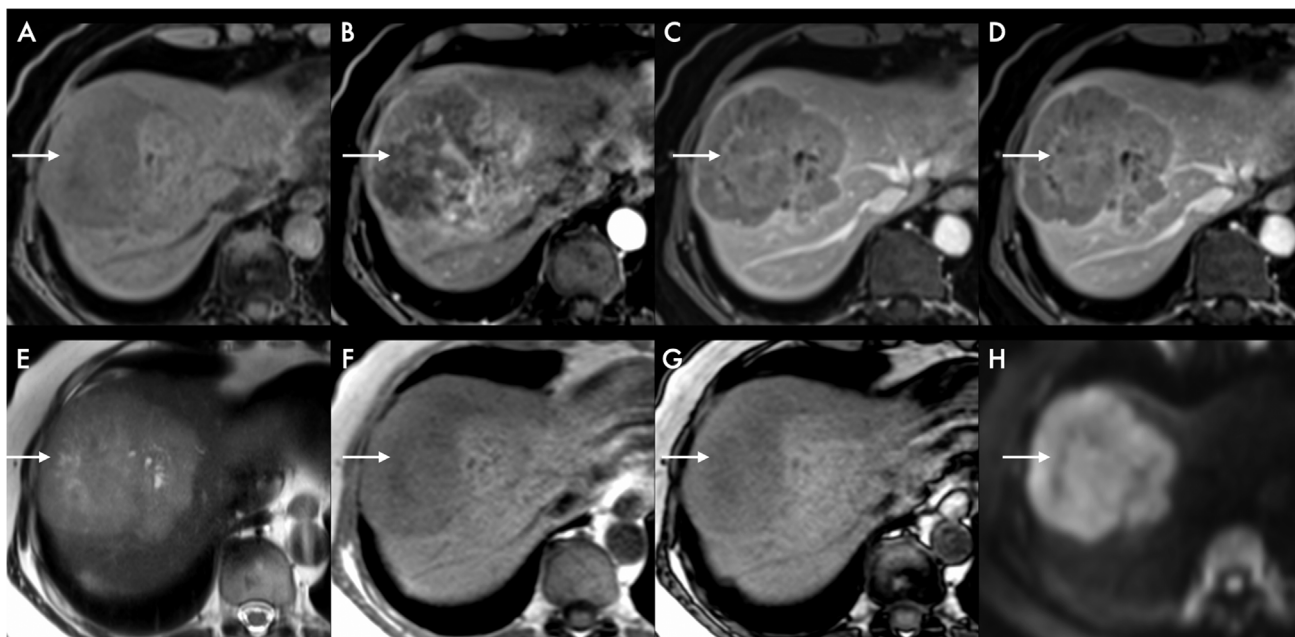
(A–C) LR-5 observation: Magnetic resonance imaging (MRI) showing the major imaging features of LI-RADS: Contrast-enhanced MRI study shows a 70 mm observation (white arrow) appearing hypointense on T1-weighted (T1W) images (A), showing heterogenous arterial phase hyperenhancement on arterial phase images (B) with washout on portal venous phase images (C) and delayed enhancing rim on delayed phase images (D). Observation appears hyperintense on T2W images (E) showing diffusion-weighted imaging hyperintensity (H), and does not contain fat in phase and out of phase (F, G).
